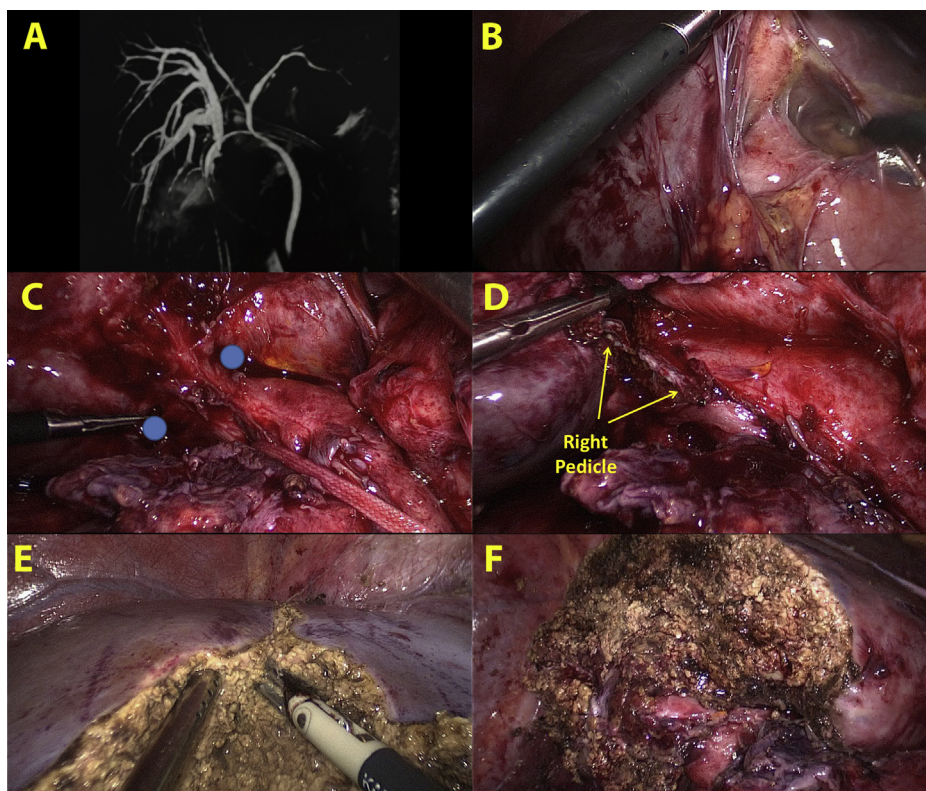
Laparoscopic right hepatectomy in a patient with complex biliary injury and multiple previous interventions. A. Preoperative MRI cholangiogram shows a dilated right bile duct disconnected from the main biliary tree. B. Multiple adhesions were found, and hepatic hilum was encumbered by previous manipulations. C. Intrahepatic approach to the right Glissonian pedicle was used. D. Two small incisions (blue spheres) were performed according specific anatomical landmarks [3]. E. Right pedicle is divided by stapler as shown (arrows). F. Liver is transected under intermittent Pringle maneuver. Raw liver surface after right hepatectomy.
